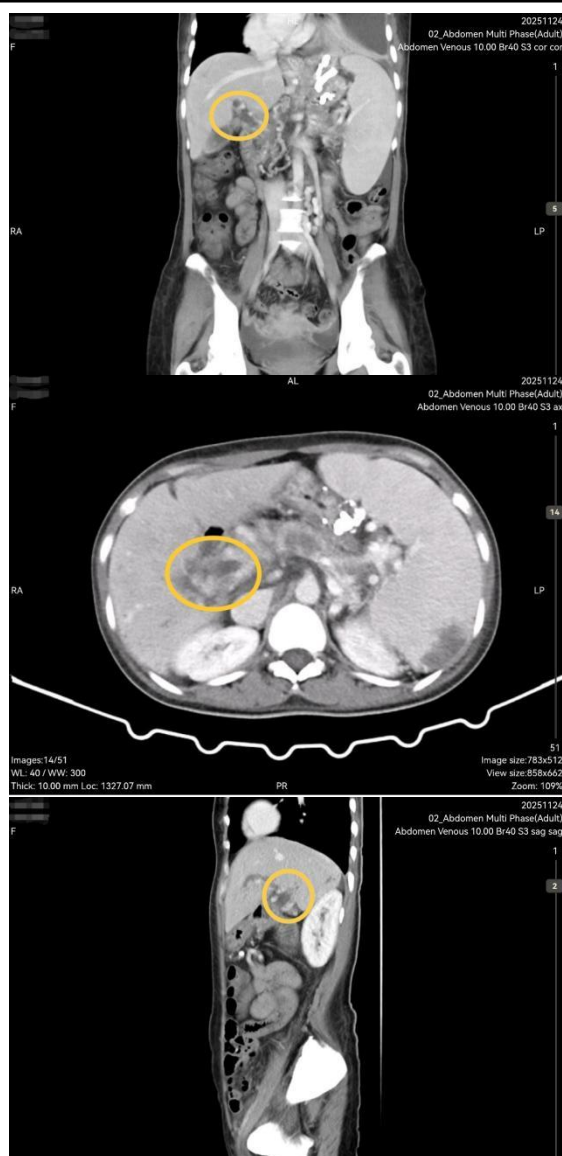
Contrast CT of the abdomen showed thrombus within the main portal vein
